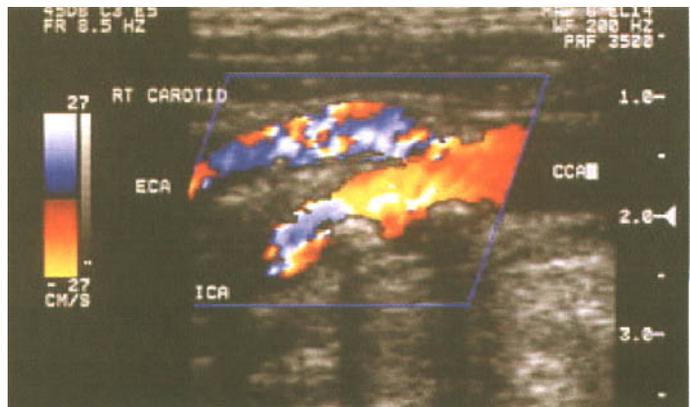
Color Doppler flow image of internal carotid artery stenosis. The velocity scale settings are low, leading to aliasing at multiple sites. However, relatively low PRF allows better delineation of plaque edges and the color flow appearance can guide the angle-corrected Doppler velocimetry.
